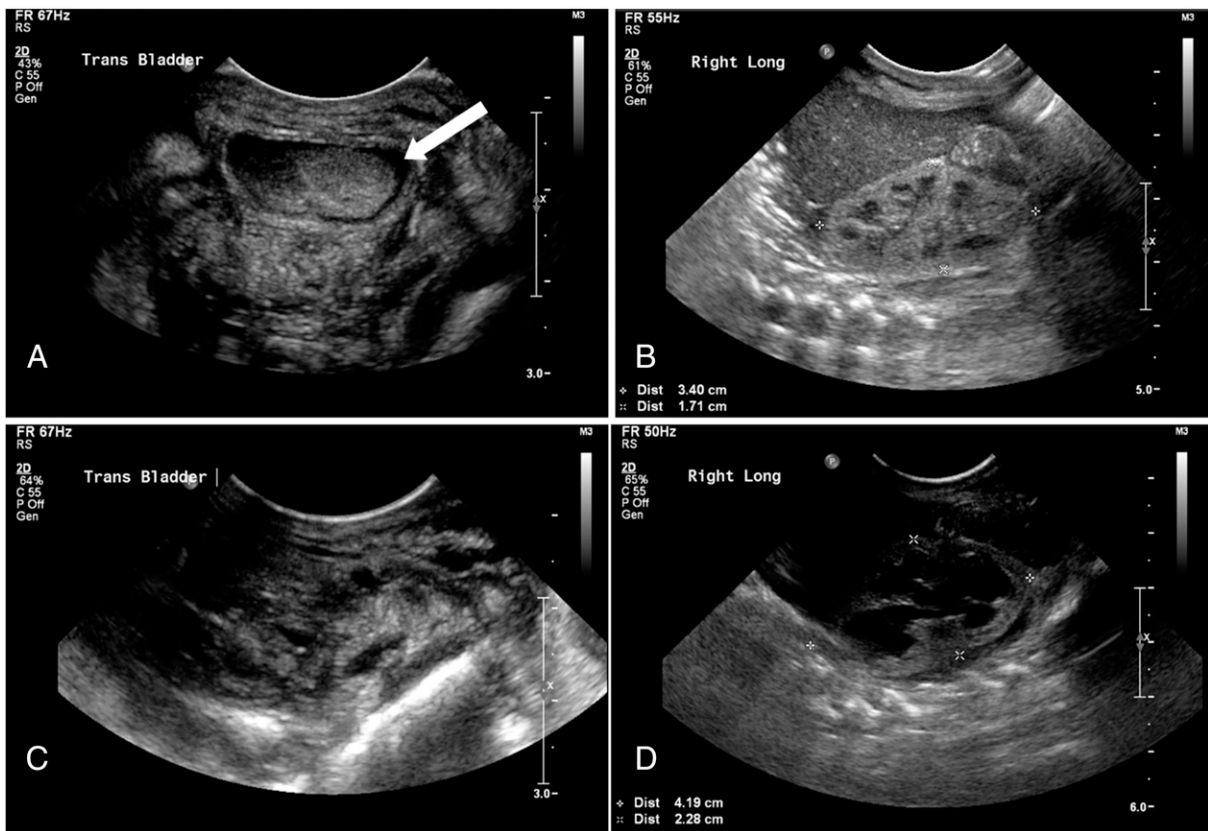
Upper panel (A and B) represents ultrasound images of bladder and right kidney on the day of initial presentation with gross hematuria. A large blood clot can be seen as an echodensity occupying the entire bladder (arrow in A). The architecture of the right kidney is well maintained at this time (B) but subsequent studies showed worsening hydronephrosis. Lower panel (C and D) represents images from a follow-up study conducted just before the nephrostomy tubes were placed. Decompressed bladder (C) and severe hydronephrosis (D) in the face of ongoing anuria were readily noted.
